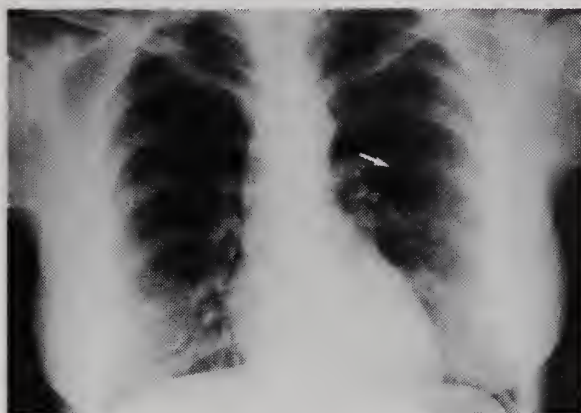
AP chest x-ray demonstrating rib notching (see arrow).
